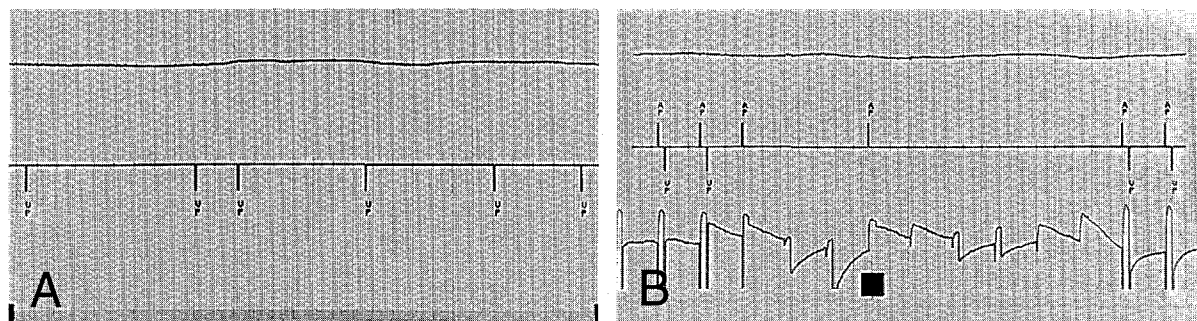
A, Interference of unipolar pacemaker activity during operation of ultrasonic scaler. Several pauses appear in ventricular pacing during operation of scaler. B, Interference of bipolar pacemaker activity during operation of ultrasonic scaler. Several pauses in ventricular and atrial pacing and erratic output are discernible.
